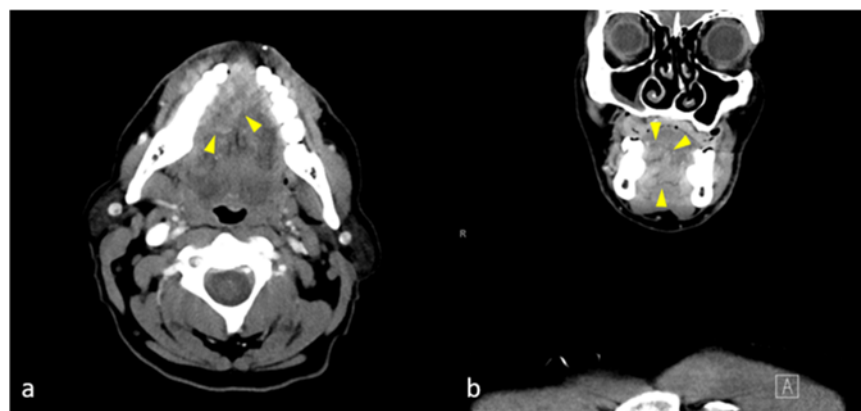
Axial (a) and sagittal (b) CT of the neck with contrast show a subtle ulcerative lesion along the right ventral surface of the tongue (yellow arrowheads). While the superficial mucosal detail of this ulcerative lesion is better identified by direct visualization, imaging is helpful to evaluate the depth of local invasion of the soft tissues as well as possible bone and lymph node involvement. Image courtesy of University of Massachusetts Medical School, Department of Radiology.
